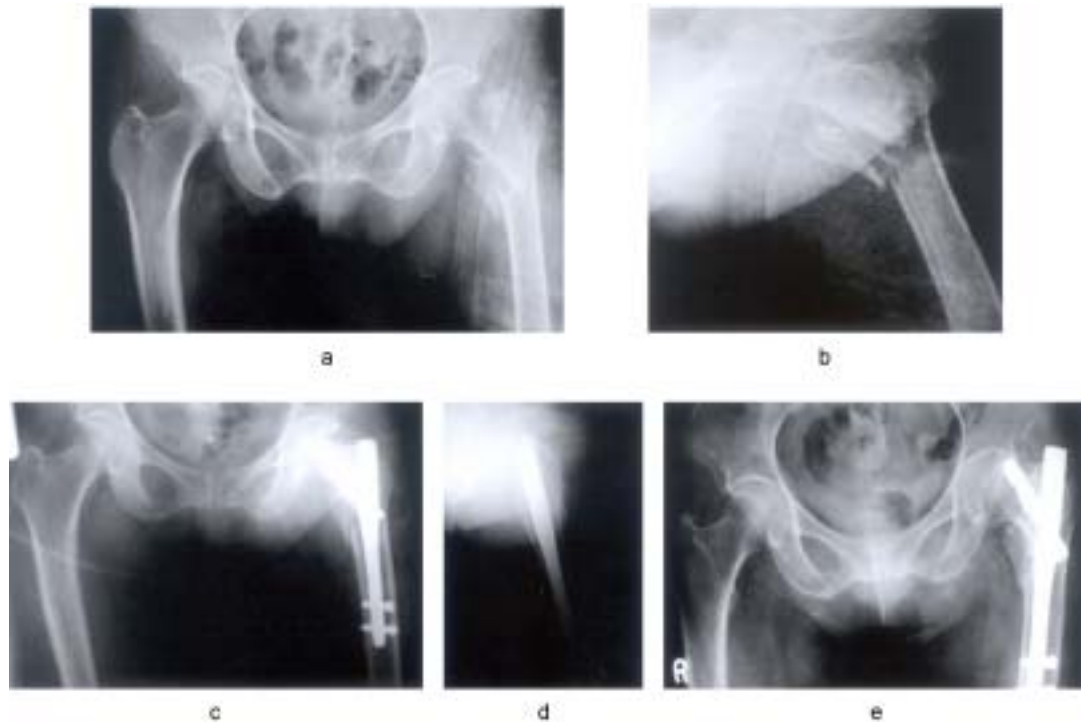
A 79-year-old female with intertrochanteric fracture on her left hip. a, b: Preoperative AP and lateral x-ray shows an unstable fracture without medial support. c, d: AP diastasis is 13 mm, postoperative displacement of lesser trochanter is 5 mm, position of lag screw is superior position and TAD is 25 mm in postoperative AP and lateral x-ray. e: Twelve months after surgery, the AP x-ray shows union failure with cutting out of the lag screw. Sliding of lag screw is 5 mm and the neck shaft angle is 120°.
